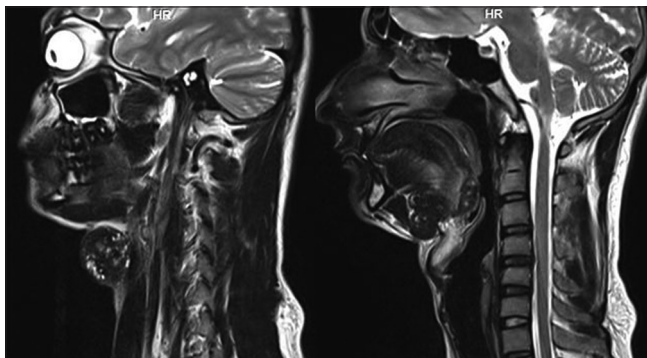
On T2-weighted sagittal magnetic resonance images, the ectopic thyroid glands appears predominantly isointense to the muscle
